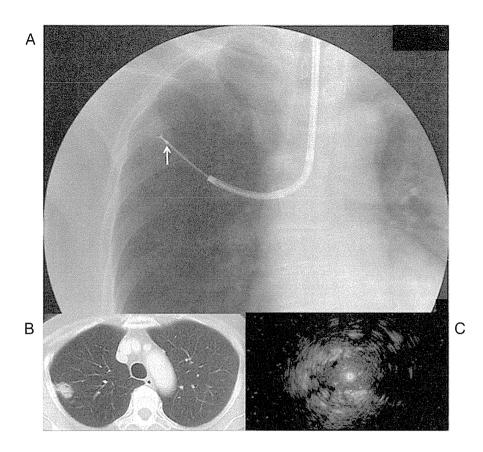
Fluoroscopic image of transbronchial biopsy using a guide sheath with a metallic marker (arrow) (A), computed tomographic image (B), and ultrasonic image of a lung cancer (adenocarcinoma) examined and diagnosed by endobronchial ultrasound-guided transbronchial biopsy with the guide sheath method (C).
